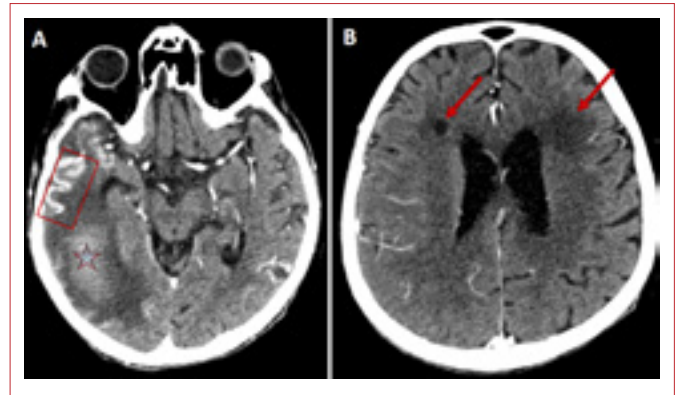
(a, b). Post-contrast control CT scans (A and B) indicating partial resolution of the right temporal hemorrhage (star) and parenchymal aspergillomas (arrows). The axial CT scan (A) also reveals contrast enhancement in the right temporal gyriform region (frame).
